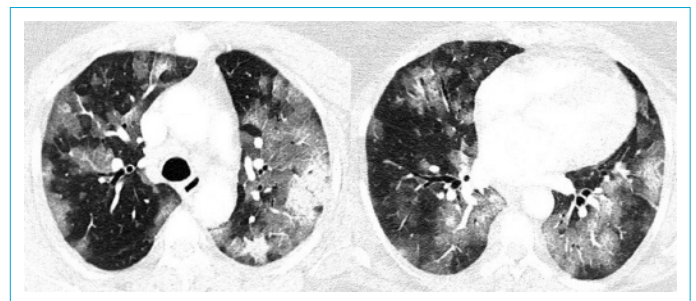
57-year-old female patient presenting with cough and fever (up to 39°C) for three days. The patient had diabetes type II and arterial hypertension. The patient presented with tachypnoea and an SpO₂ of 68%. As respiratory failure was evolving (Horovitz quotient 65 mmHg), the decision was made to intubate the patient and to start ventilation. Chest CT was performed to rule-out pulmonary embolism and showed extensive bilateral ground-glass opacities and consolidations similar to previous reports.^[6, 7]
